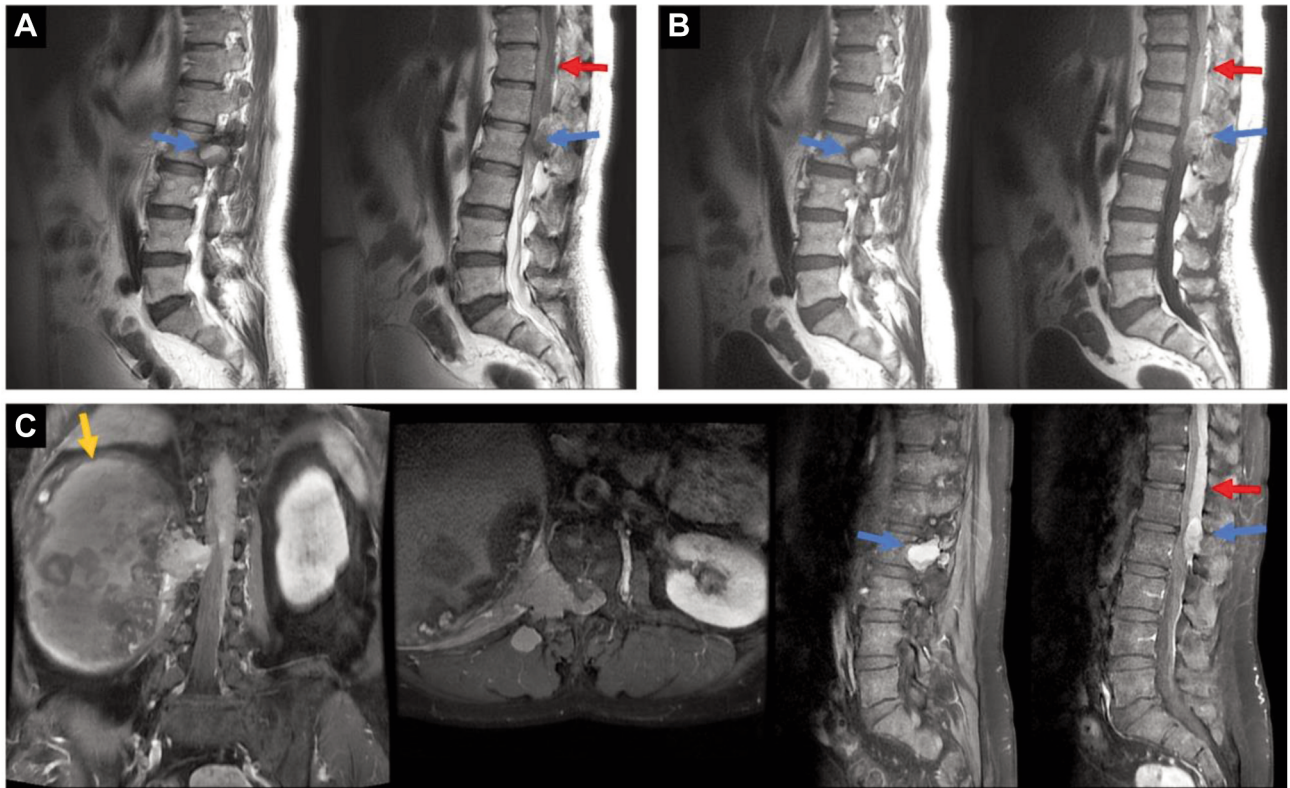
L-spine contrast-enhanced MRI showed the precise location of the suspected tumor. A huge mass can be seen in the right retroperitoneum (orange arrow), with smaller components in the enlarged right L2-L3 foramen (blue arrow), continuously with long posterior epidural lesions from at least T10 to upper L5 level (red arrow). The tumor has hemorrhage or melanin content. (A) T2-weighted. (B) T1-Weighted. (C) Gadolinium enhanced coronal, axial and sagittal views. MRI: Magnetic resonance imaging.
